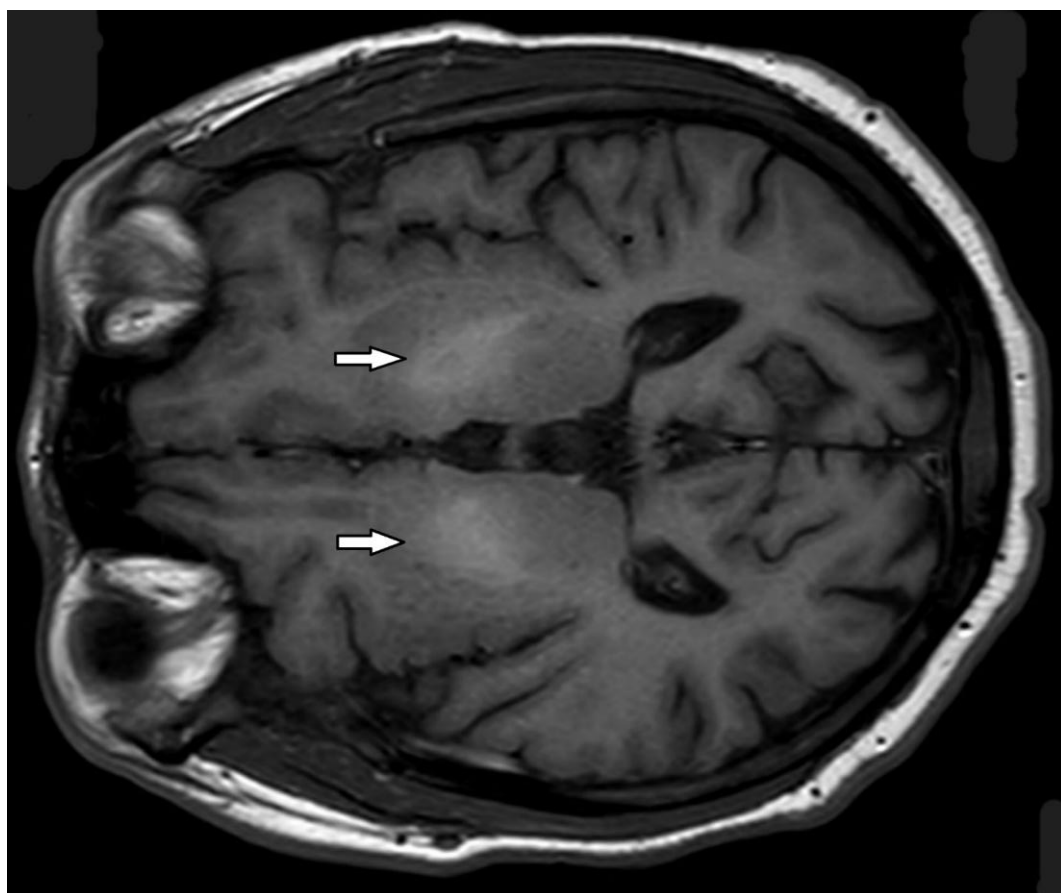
Brain MRI revealing cortical atrophy and hyperintensity in the globus pallidus bilaterally on T1 weighted sequences, suggesting acquired hepatocerebral degeneration in this clinical context.
